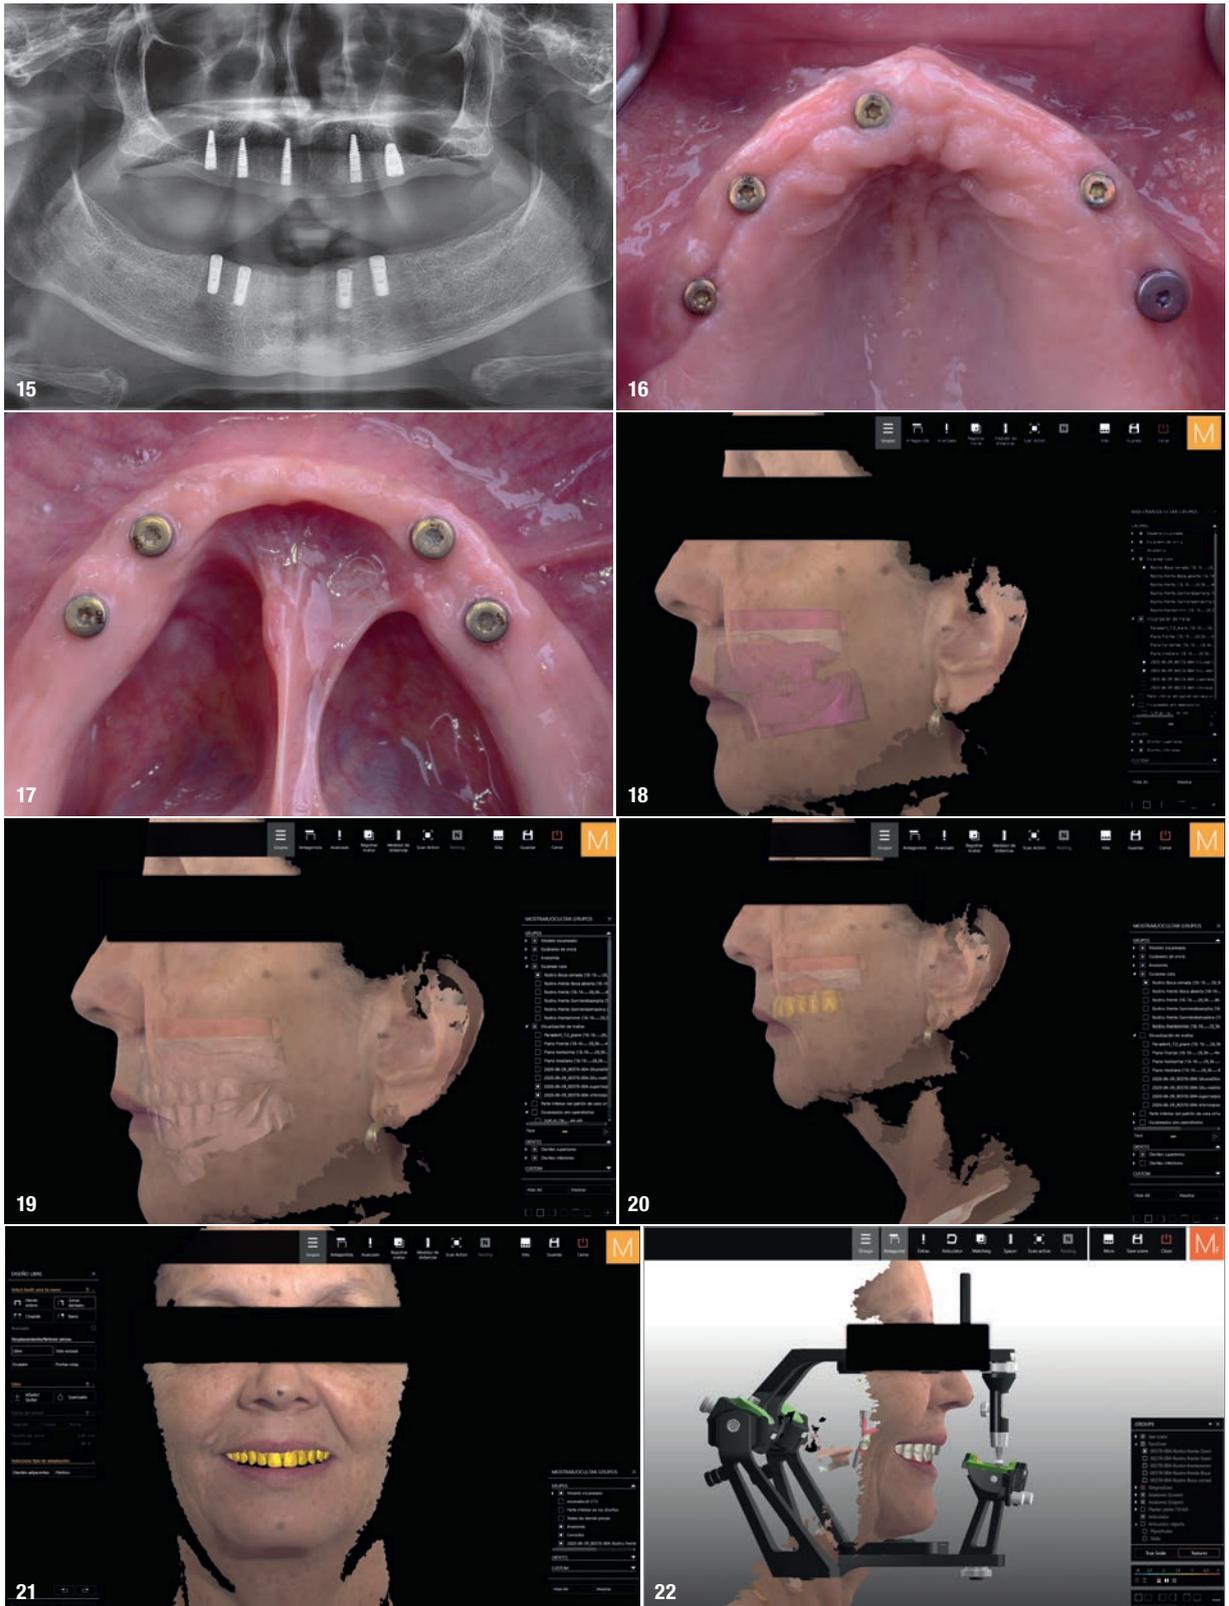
Panoramic radiograph after the eight-week post-op healing period. Fig. 16: Occlusal view of the five uncovered maxillary implants. Fig. 17: Occlusal view of the four uncovered mandibular implants. Fig. 18: 3D digitisation of the patient's face in the natural head position with maxillary and mandibular baseplates and wax rims with the correct intermaxillary parameters. Fig. 19: Facial data integrated into the virtual articulator with final virtual design of the restorations. Fig. 20: Facial data integrated into the virtual articulator with final virtual design of the maxillary restoration. Fig. 21: Facial data integrated into the virtual articulator with final virtual design of the maxillary restoration. Fig. 22: Facial data integrated into the virtual articulator with final virtual design of the maxillary and mandibular restorations.
